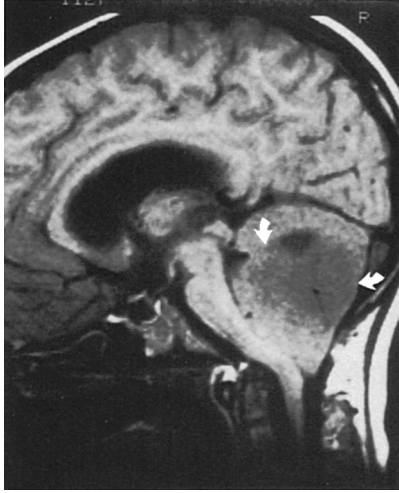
Magnetic resonance imaging (MRI) scan of medulloblastoma. Sagittal T1-weighted image shows a hypointense mass involving the vermis (*arrows*). (From Kuhn JP, Slovis TL, Haller JO. *Caffey's pediatric diagnostic imaging*. 10th ed. Philadelphia: Mosby, 2004, p. 574.)
